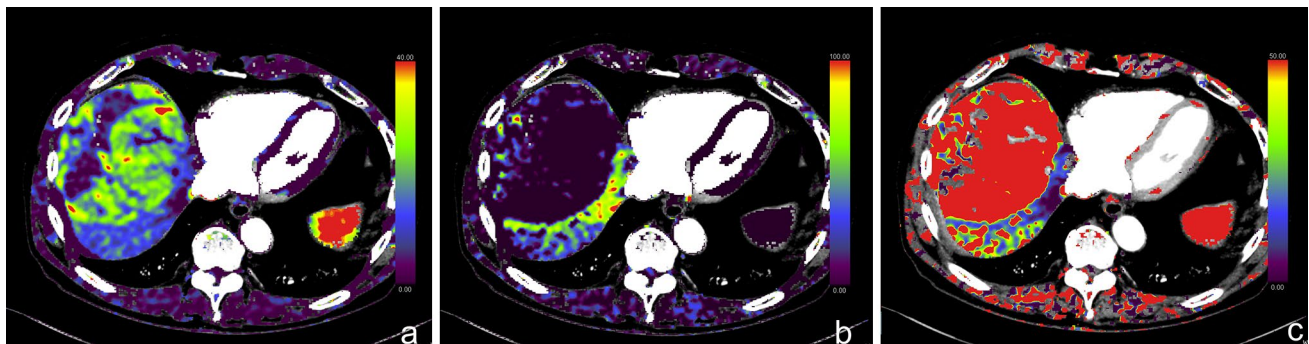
Volume Perfusion CT, male, 67 years old, hepatocellular carcinoma. A–c: model-free maximum slope. The hepatocellular carcinoma has significantly higher arterial perfusion (a) and lower portal
